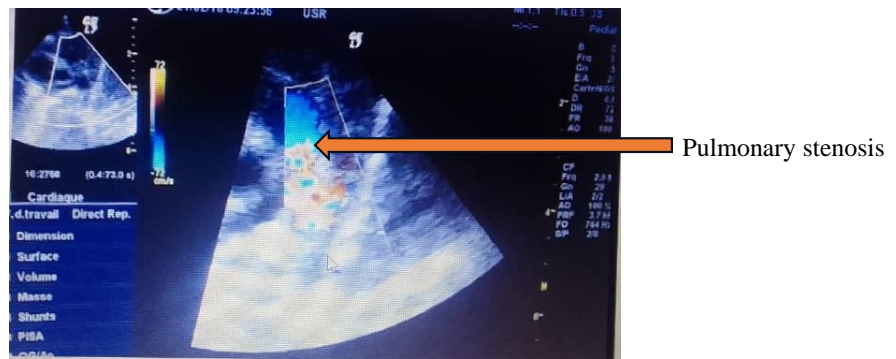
Image of heart ultrasound of patient 2.
